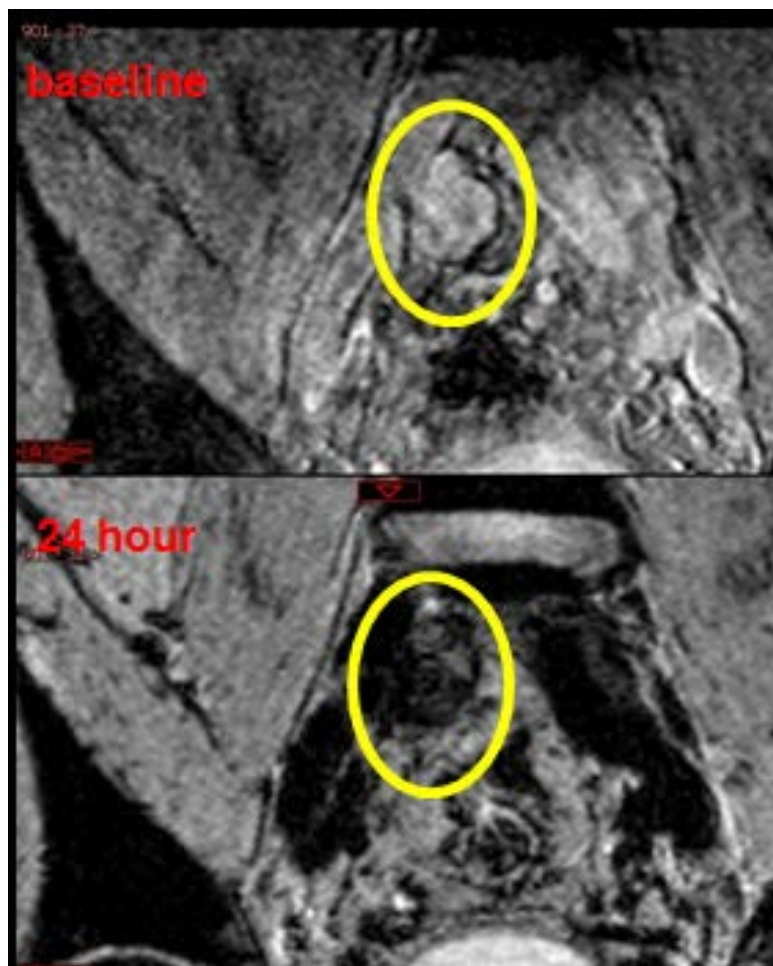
Coronal T2* weighted MRI at the baseline scan demonstrates an enlarged right common iliac chain lymph node, 24hr follow up scan after 7.5mg Fe/kg Ferumoxytol injection demonstrate a heterogenous signal pattern with partial hyperintense focus within the lymph node, which is suspicious for partial malignant involvement.
